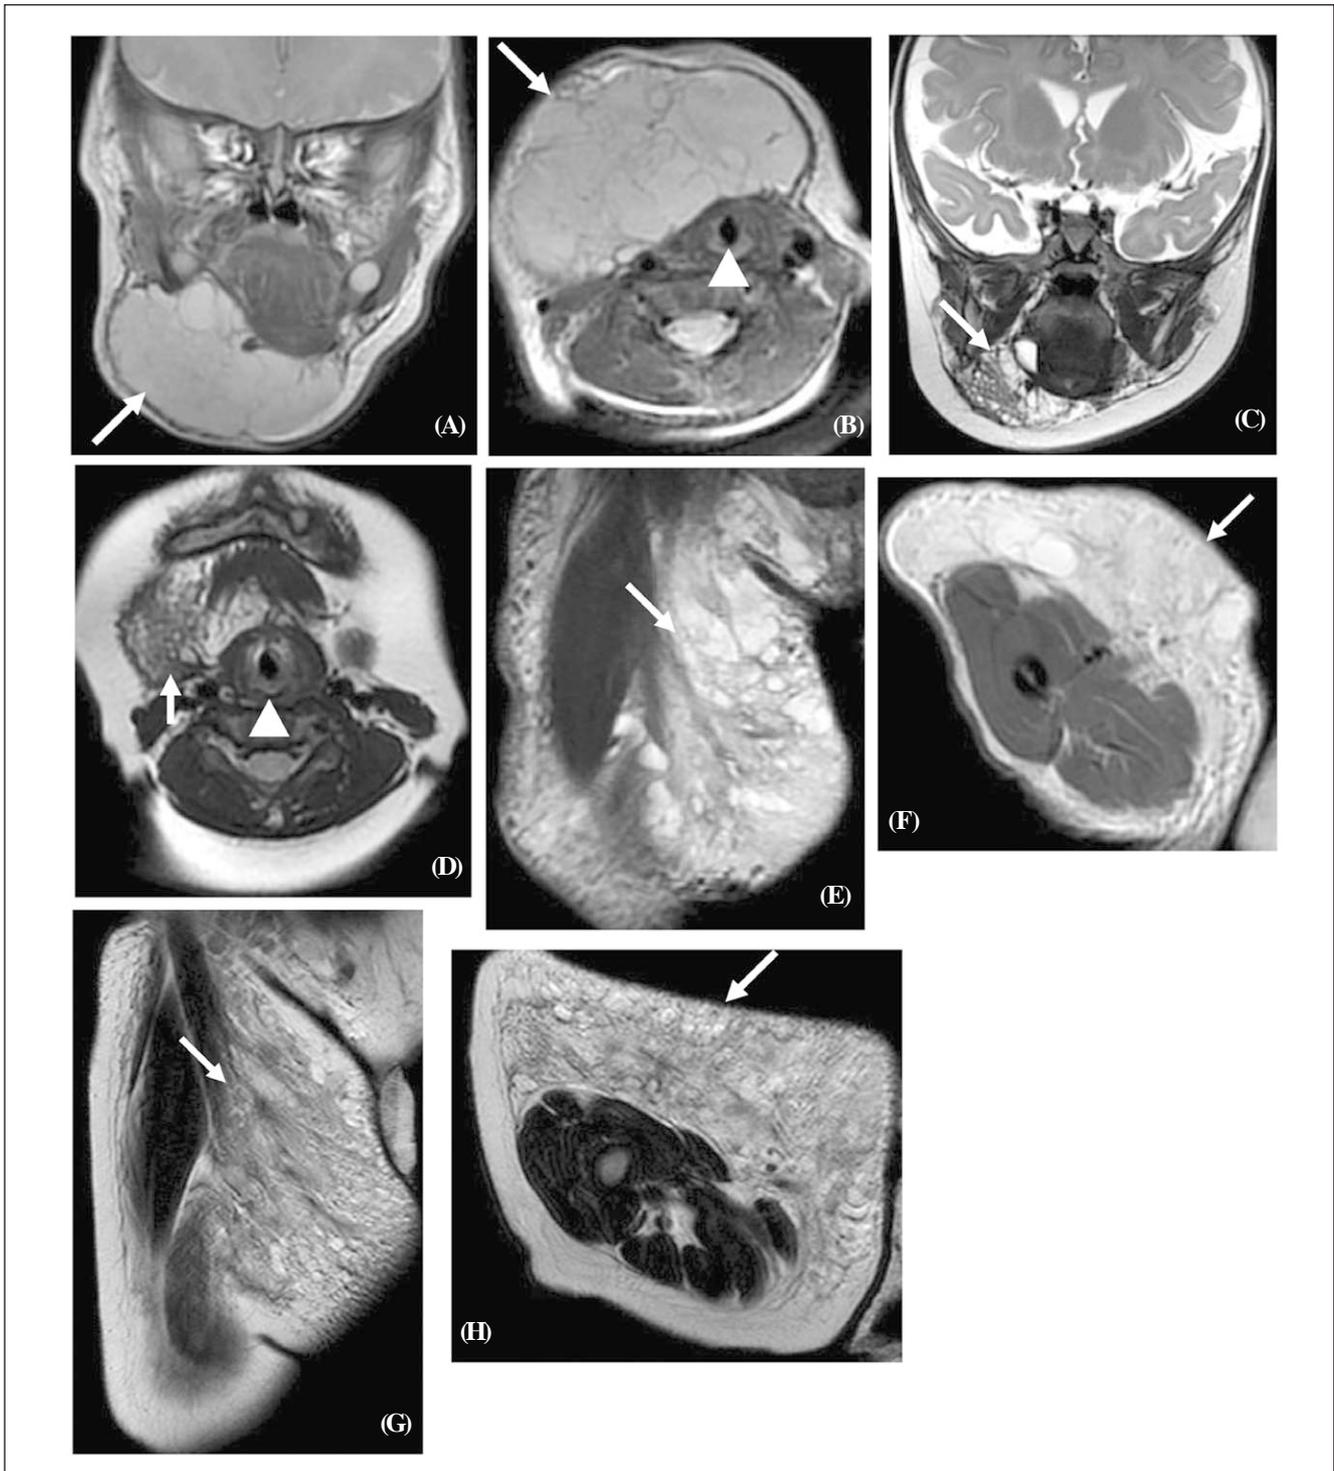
Magnetic resonance imaging (MRI) scan (T2-weighted image).
